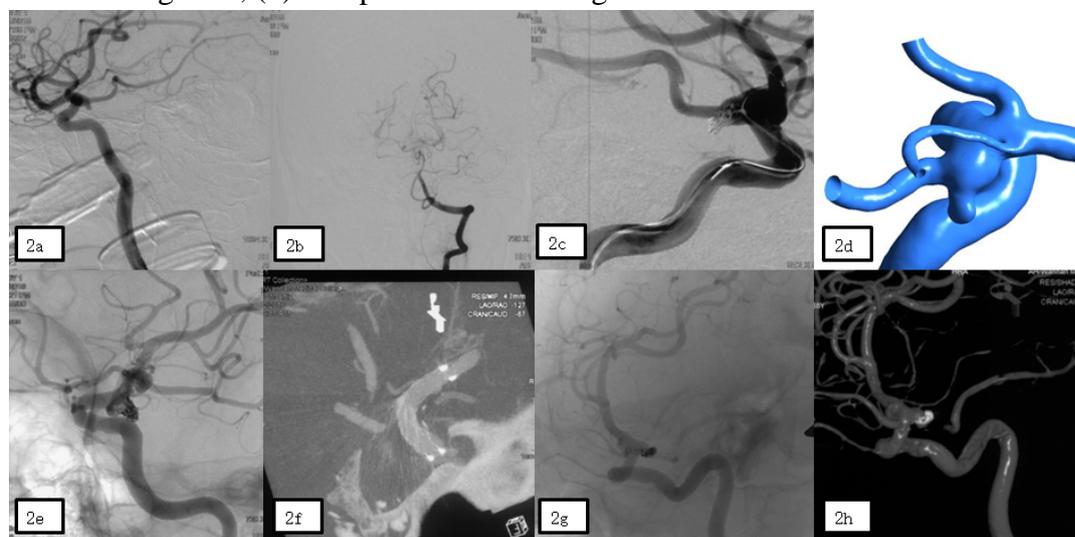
Posterior communicating aneurysm at the conical dilation with fetal-type posterior cerebral artery. (a) Right posterior communicating aneurysm at the conical origin; (b) Angiography of vertebral artery, no blood supply from vertebral artery to posterior cerebral artery when compressing the right internal carotid artery; (c) Stent-assisted embolization; (d) 3D image of the aneurysm; (e) Stent implanted in the cone, immediate angiograph right after procedure; (f) Dyna CT showing good stent deployment in the posterior communicating artery and internal carotid artery; (g) Partial contrast filling of sac, and partial coil displacement at 18-month follow-up; (h) 3D image during follow-up.
